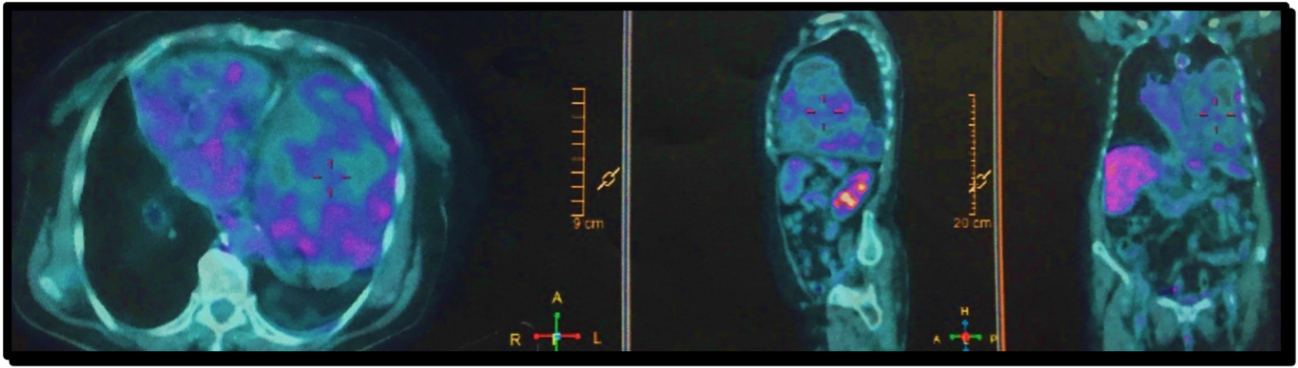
Positron emission tomography-computed tomography (PET-CT) scan confirmed the huge dimension of the lesion, which appeared to invade the pericardium, the mediastinum, and the hemidiaphragm. A, Anterior; R, Right; L, Left; H, Head; P, Posterior.
